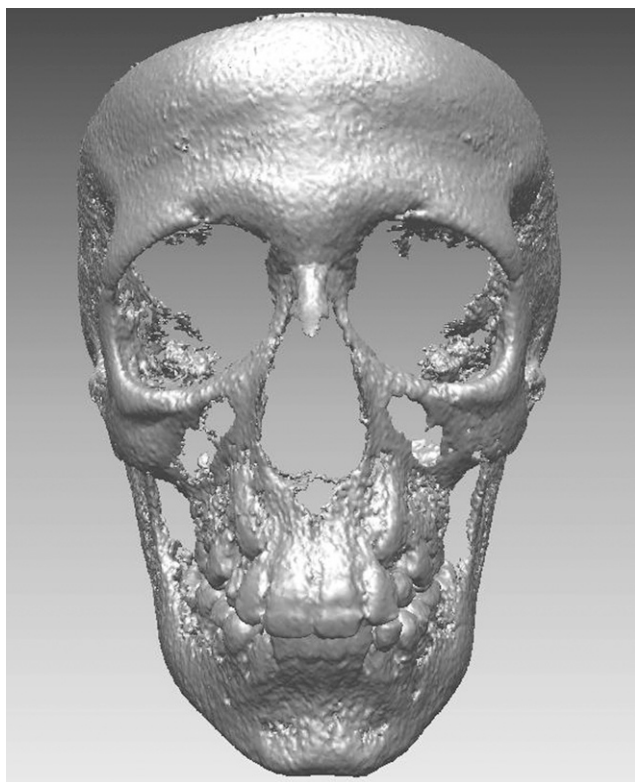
Three-dimensional reconstruction of the skull from cone beam CT using a NewTom scanner
